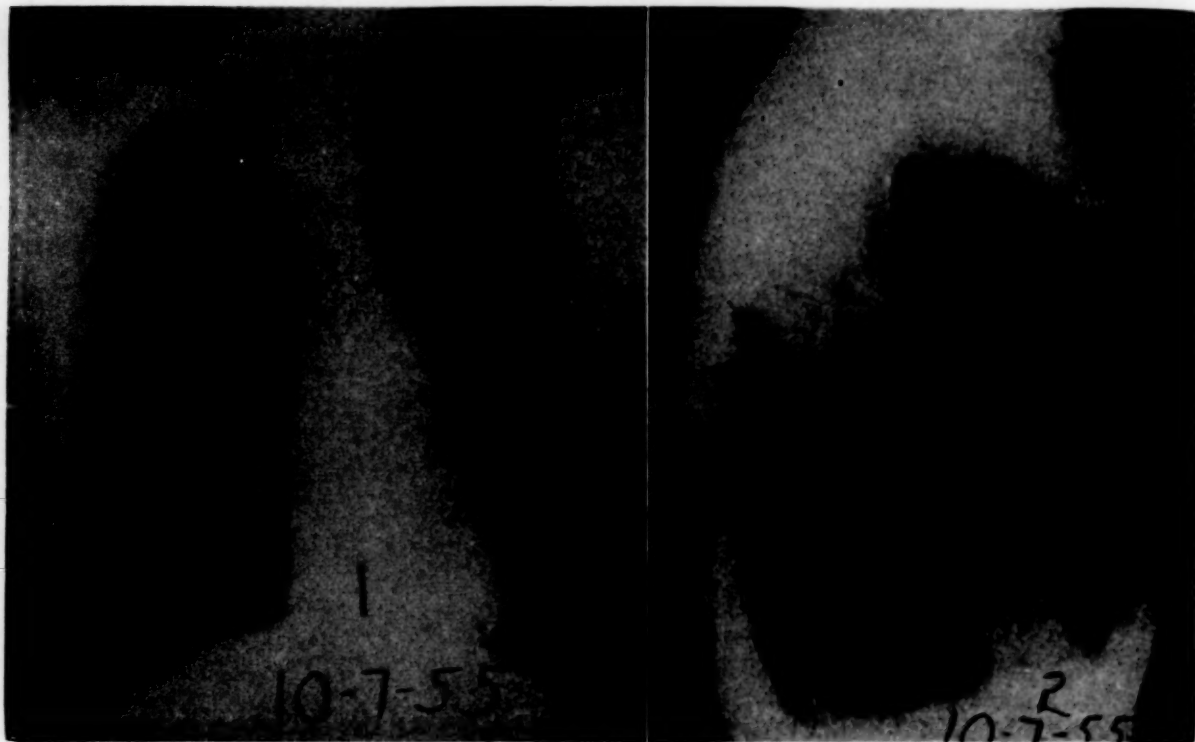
CASE IX. Preoperative roentgenograms showing bullae in right upper chest with downward displacement of hilar structures.
